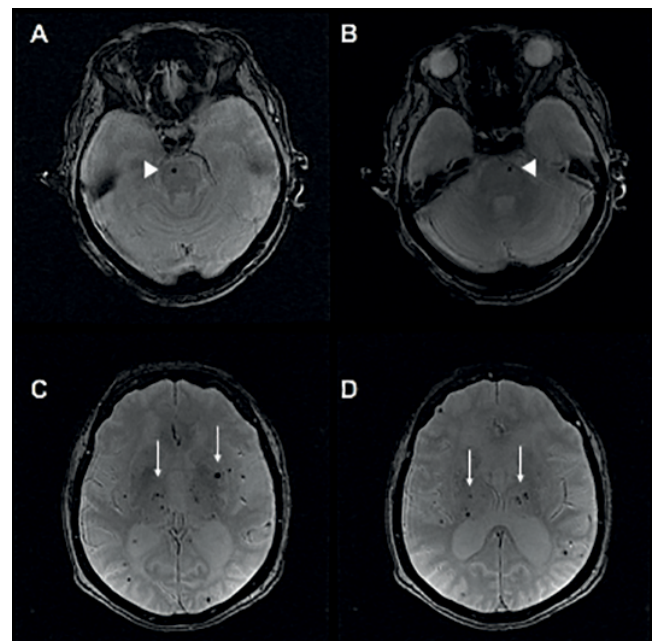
1.5T axial brain MRI, T2* GRE sequences. Distribution of cerebral microbleeds (CMB). A-B: CMB located in the brainstem/pons (arrowhead); C-D: Mixed distribution (lobar and deep location), with CMB in internal capsule, basal ganglia and thalamus (white arrows). In these situations, diagnosis of cerebral amyloid angiopathy is excluded.
